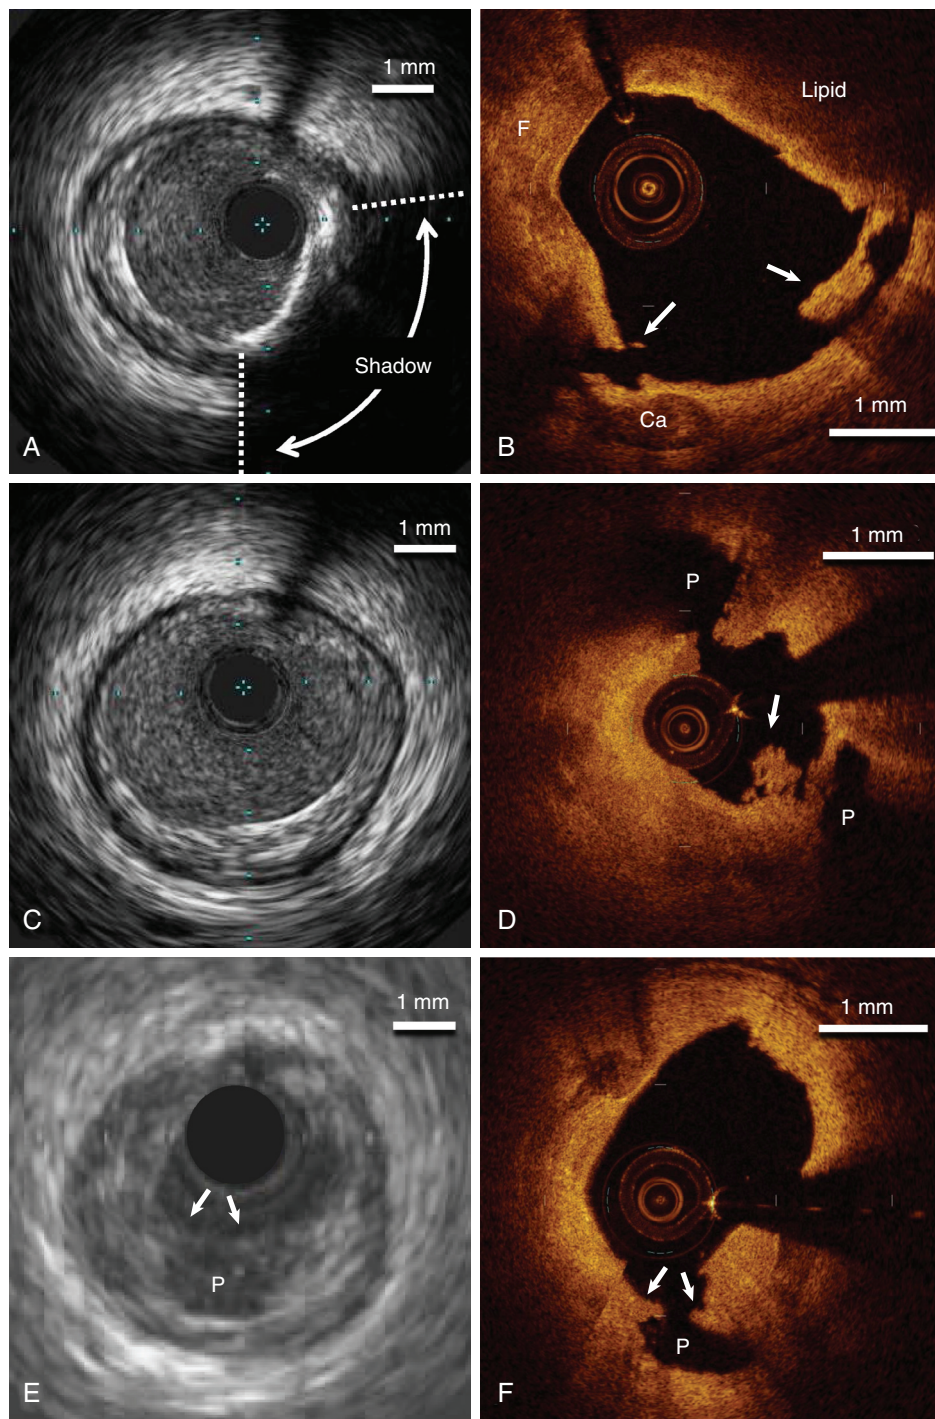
A, IVUS image showing bright echogenic signal from 3 to 6 o'clock with shadow characteristic of a calcified plaque. B, OCT image of a plaque showing fibrous tissue with a homogeneous signal (F), lipid plaque with a signal-poor region with ill-defined borders (Lipid), and a signal-poor region with well-defined borders typical of calcium (Ca). The arrows indicate dissections in the intima. C, IVUS image showing a homogeneous signal typical of a fibrous plaque. D, OCT image of a stenosis from an acute coronary syndrome showing an irregular-shaped lumen defect typical of thrombus (arrow) and two cavities at 11 o'clock and 4 o'clock typical of ruptured plaques that have emptied the contents of underlying lipid pools (P). E, IVUS image showing a ruptured plaque with the remnants of a lipid pool (P) and the thin fibrous cap (arrows). F, OCT image showing a ruptured plaque with the remnants of a lipid pool (P) and the thin fibrous cap (arrows). (E, From Kinlay S: *What has intravascular ultrasound taught us about plaque biology?* *Curr Atheroscler Rep* 3:260, 2001.)
